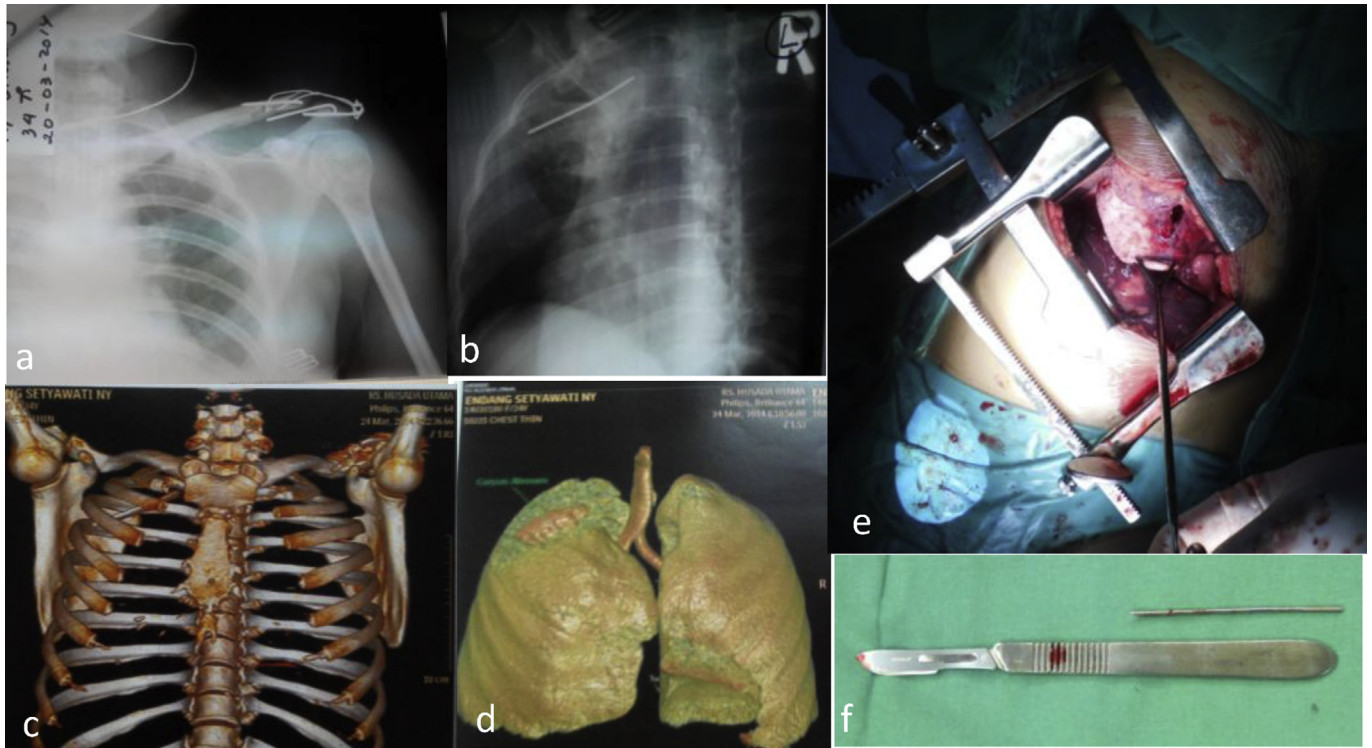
Trans thoracic migration of K-wire. (a) Tension Band Wire after 1 year (b) X Ray picture one K wire migrate to the right lung (c) CT Scan show location of K wire in right thorax (d) MRI showed K wire in the right lung (e) K-wire in lung parenchym (f). Length of K-wire after removal.
